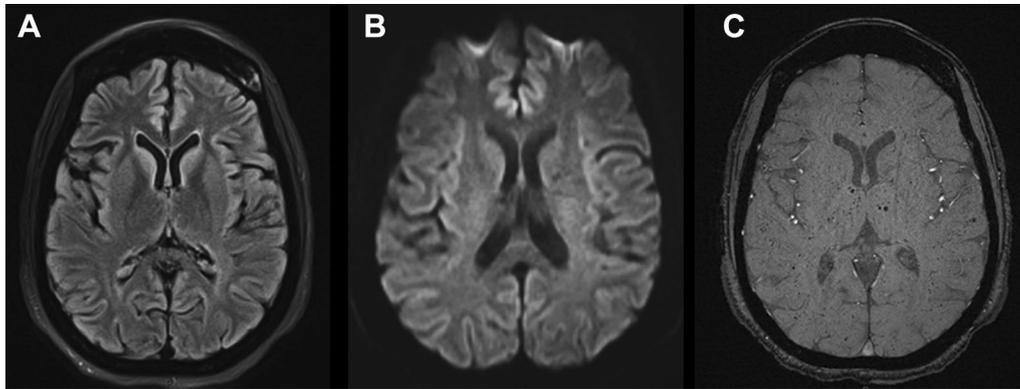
MRI 1 month later. a Axial fluid-attenuated inversion recovery (FLAIR) imaging showing total regression of the previous splenial lesion. b Diffusion-weighted imaging (DWI) is normal. c Susceptibility weighted magnetic resonance sequences (SWAN) showing partial microbleeds resorption
